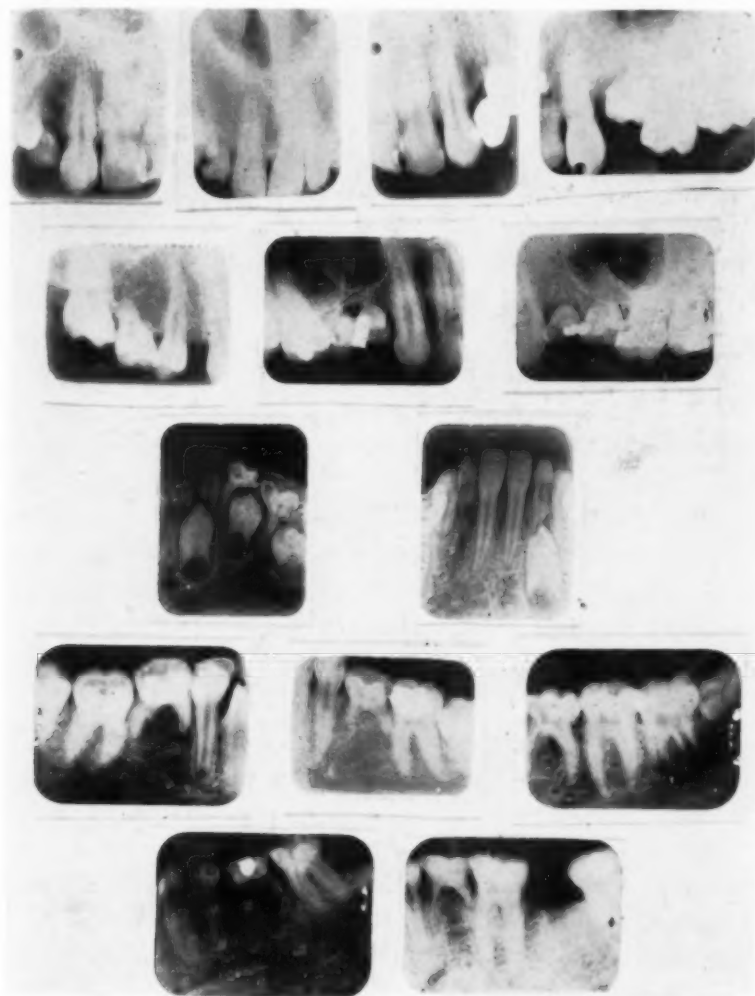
Roentgen films showing missing teeth (oligodontia).
